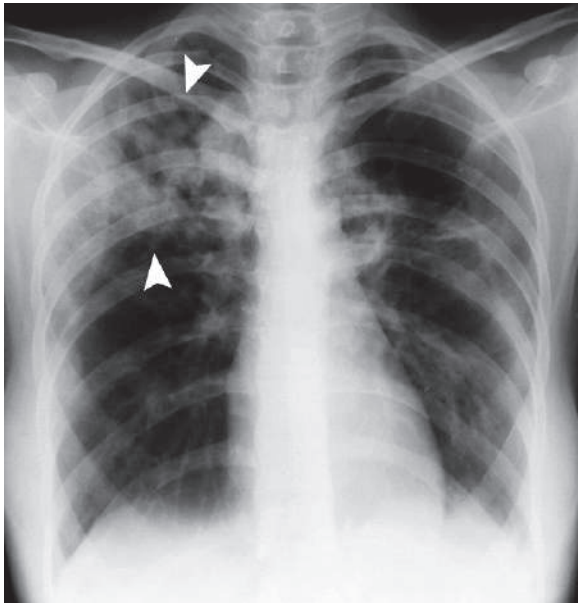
Posteroanterior chest radiograph of a patient with adult pulmonary Langerhans' cell histiocytosis (PLCH) shows multiple pulmonary nodules with different sizes located at the right upper lung zone (arrowheads)
